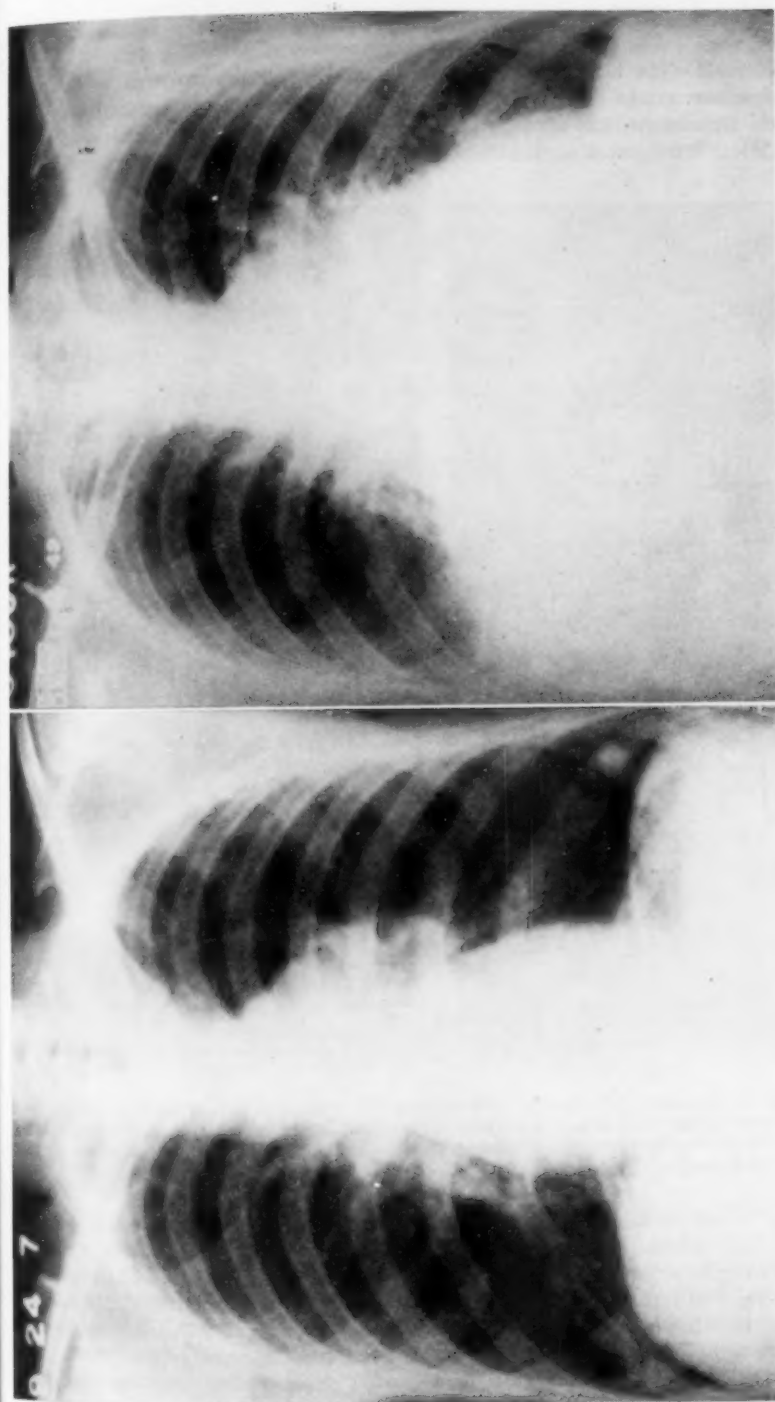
Roentgen-ray on September 24, 1947, showing enlarged nodes in left hilar region, a normal cardiac silhouette and linear nodular infiltrations in right lower lung.
